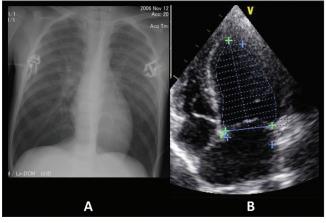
A chest X-ray showing concomitant neurogenic pulmonary edema (a). Transthoracic echocardiography showing the characteristic takotsubo-shaped left ventricle (b, shadowed)
